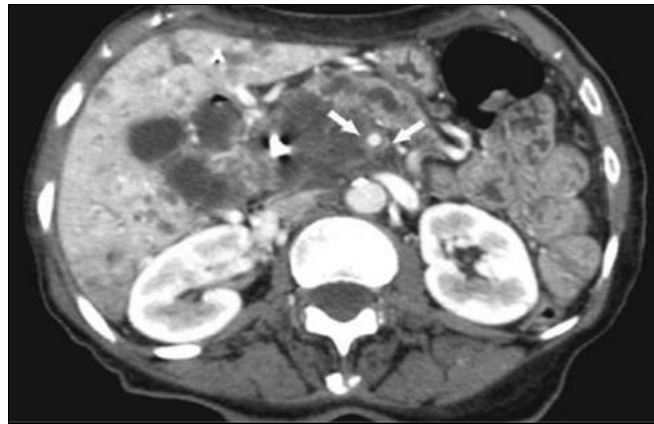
CT image shows a tumor in the head of the pancreas
